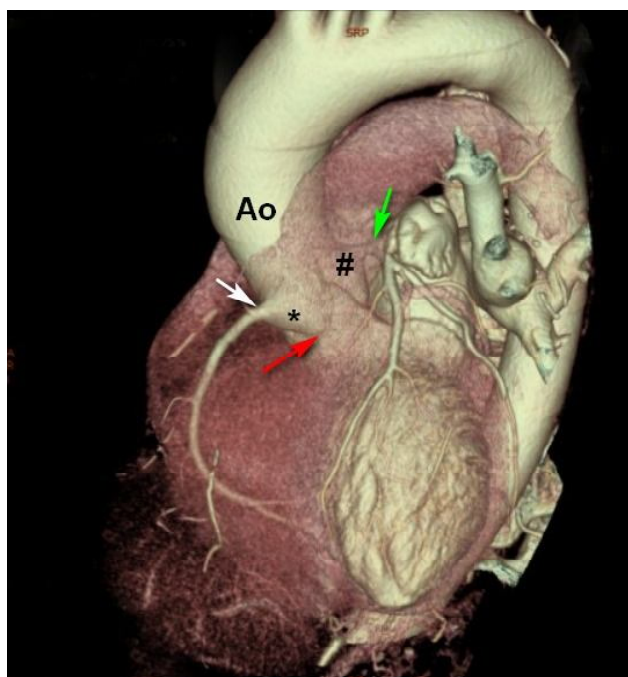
Contrast-enhanced computed tomography of the chest. CT image visualizes the ascending aorta (Ao), aortic valve (red arrow), sinuses of Valsalva (white arrow), left coronary artery orifice (#).
